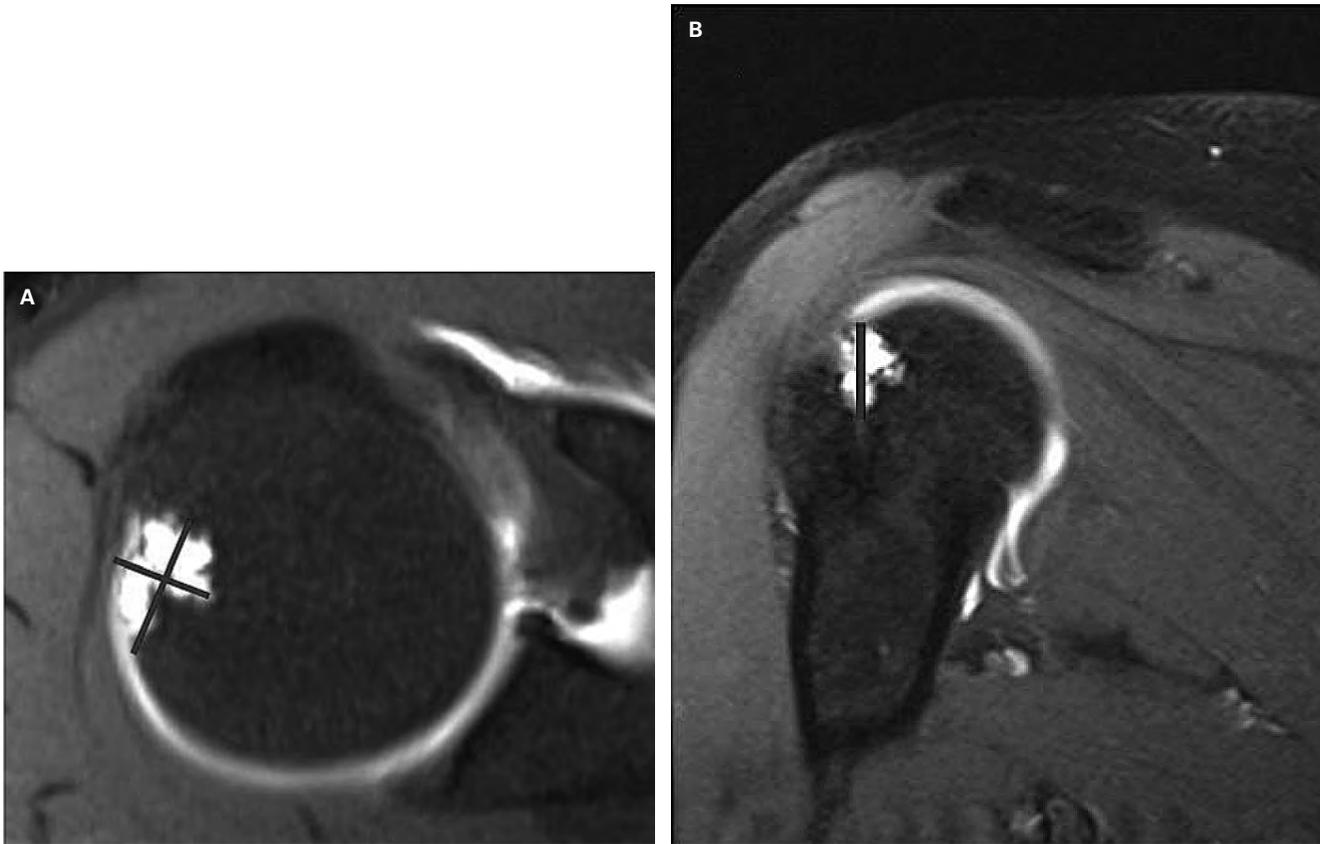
Coronal (A) and Sagittal (B) T2-weighted magnetic resonance imaging of the left shoulder. Figure 2. Demonstration of the triaxial method. (A) The fat saturated T1-weighted image with the largest cross-sectional area of the Hill-Sachs contour deformity has been identified. The longest axis has been measured (12.7 mm), along with a perpendicular short axis (9.8 mm). (B) The lesion is then triangulated on an orthogonal plane in order to directly measure its height.
